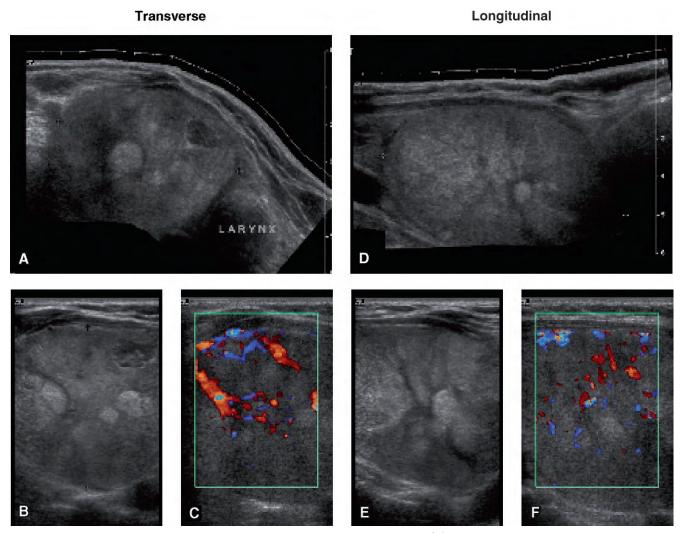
Ultrasound of follicular adenoma in the right lobe. A, Transverse, 40 x 50 mm. B, Transverse. C, Color Doppler, transverse. D, Longitudinal, sagittal diameter: 66 mm. E, Longitudinal. F, Color Doppler, longitudinal.
